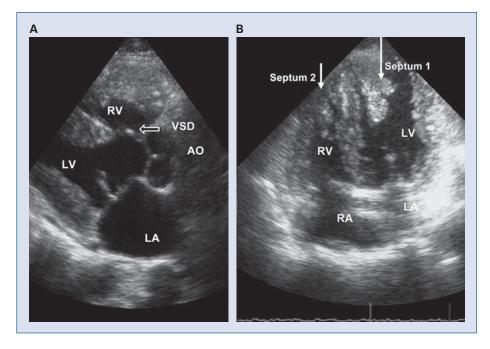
Parasternal long axis view shows the perimembranous ventricular septal defect (VSD) (A), apical four chamber view shows the two accessory septums parallel to the real septum (B); RV — right ventricle; LV — left ventricle; RA — right atrium; LA — left atrium; AO — aorta
